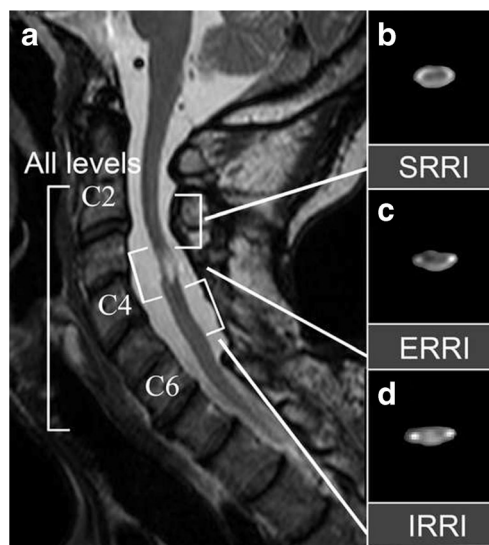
Identification of regions relative to injury (RRI). a Sagittal T2-weighted (T2-w) images were used to demarcate subject-specific injury regions. Three regions relative to injury—regions superior to injury epicenter (SRRI; b), at injury epicenter (ERRI; c), and inferior to injury epicenter (IRRI; d)—were identified, where ERRI was defined as the injury epicenter, and SRRI and IRRI were defined as one vertebral level above and below the ERRI region. The entire length of the cervical spinal cord spanning the vertebral levels C2 to C6 was defined as the all level (AL) region. Representative axial views of fractional anisotropy (FA) maps for each corresponding RRI regions are shown in b–d, without diffusion direction color-coding
